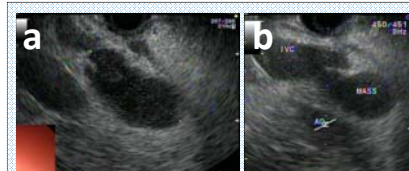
Endoscopic ultrasound allows excellent visualization of solitary enlarged retroperitoneal lymph node prior to biopsy. (a) Lymph node lies directly posterior to probe in transverse duodenum and is hypochoic. (b) Lymph node is positioned precariously adjacent to critical structures. IVC, inferior vena cava; MASS, lymph node; AO, aorta.
